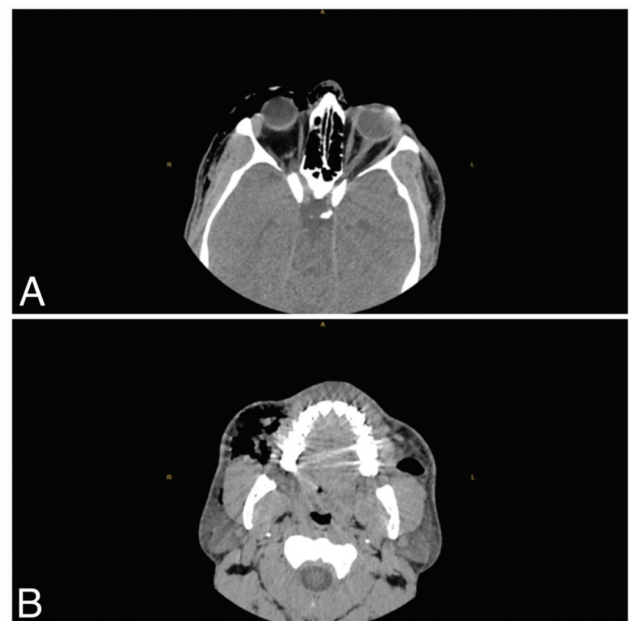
Computed tomography image. (A) Air spaces in the right periorbital and extraconal area. (B) Air spaces in the premaxillary region and masticator space.
